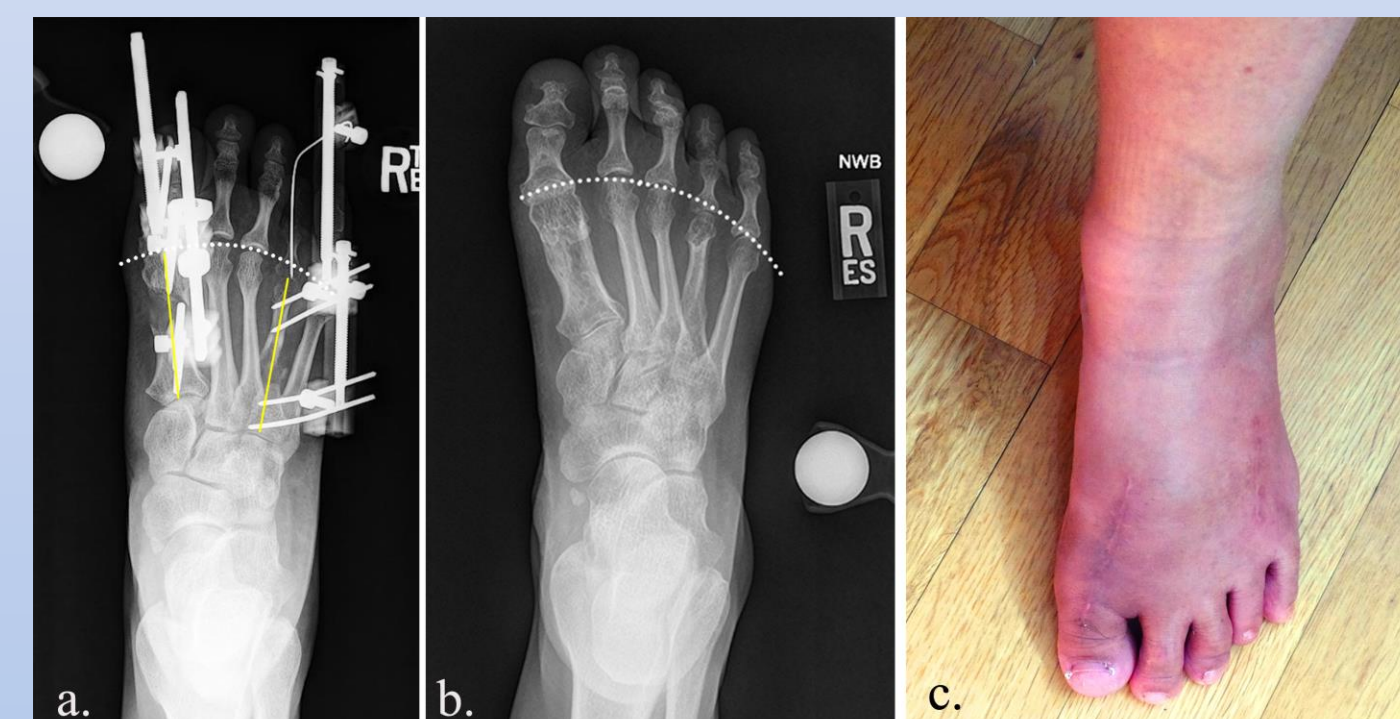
a. Anteroposterior (AP) radiograph of the foot 4 weeks post-operatively. The yellow lines represent the mid-diaphyseal lines of the 1st and 4th MTs extending towards the most proximal and distal ends for MT length measurement. The radiograph demonstrates achievement of planned first metatarsal length where the 1st MT head lies on the MT head parabolic arc. The fourth MT was found to be 3 mm short and distraction was resumed. Note the K-wire transfixing the 4th MTP joint. This wire was removed 4 weeks later (8 weeks post-operatively). b. Final AP radiograph of the patient's foot 8 months post-operatively showing complete consolidation of the bone regenerate and almost complete restoration of the MT parabolic arc. The 4th MT was 1.5 mm short of the arc but c. the clinical appearance of the 4th toe had an ideal cosmetic outcome. She had mild residual stiffness of both 1st and 4th MTP joints 1 year post-operatively.
